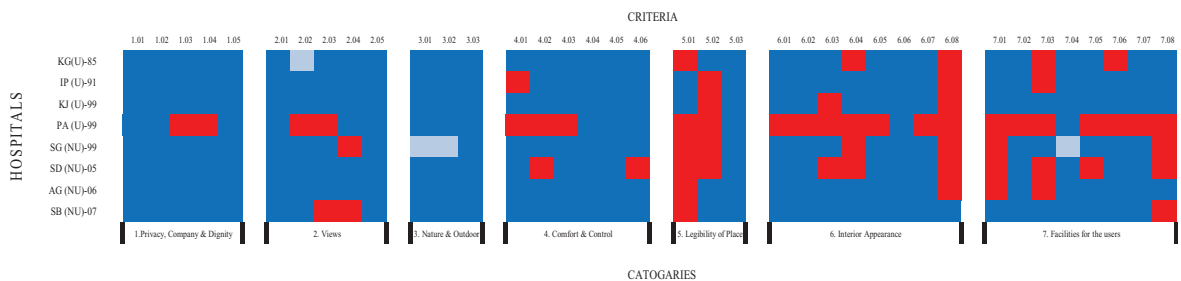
(b): The ASPECT (A Staff and Patient Environment Calibration Toolkit). Summary of Findings (Patients, N=217)
